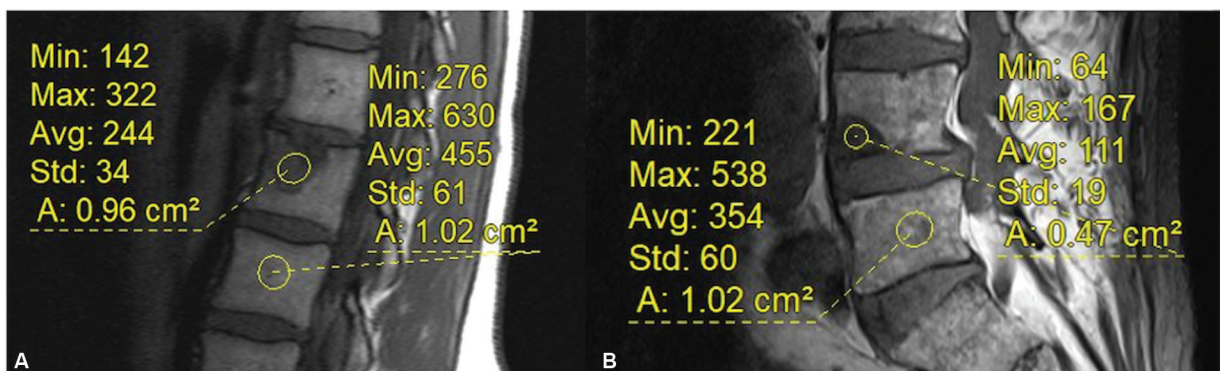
Sagittal T1-weighted images from the metastatic cohort showing calculation of T1 ratio of marrow of the metastasis/ normal marrow in two different patients. The ratio in part (A) is 0.53 and in part (B) is 0.31.
